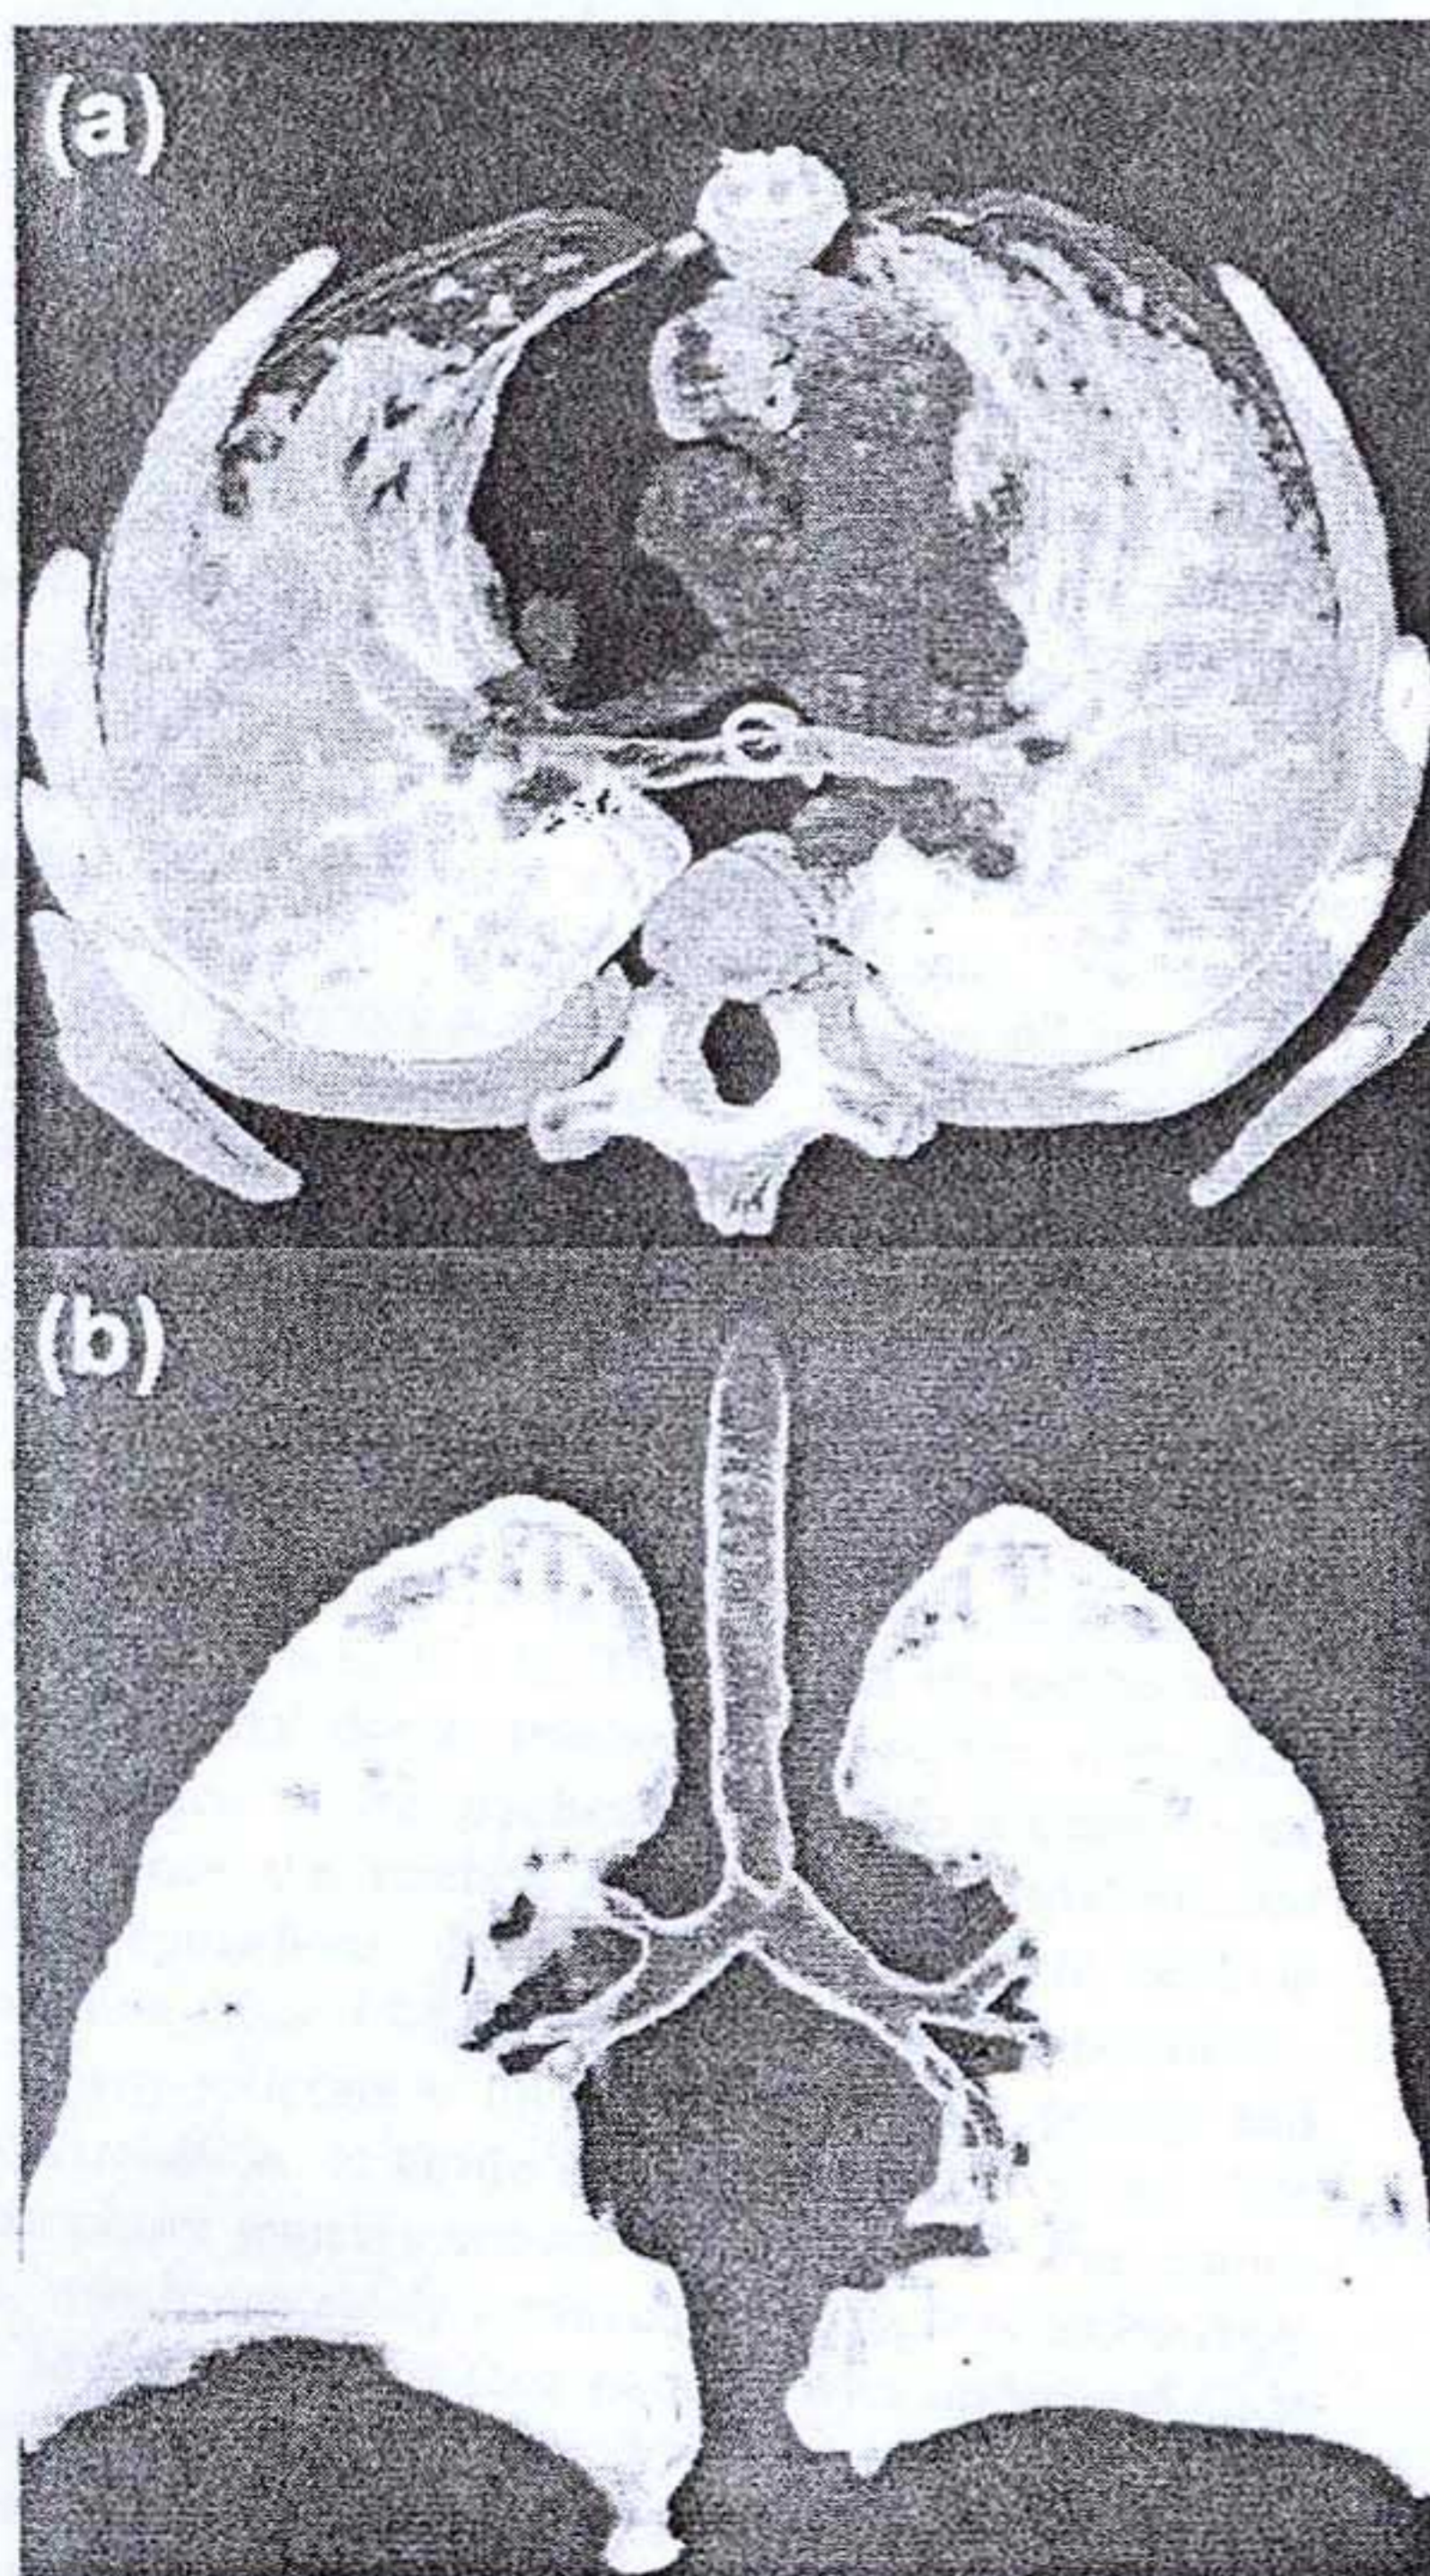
Postoperative 3D computed tomography of a 6-month-old baby after slide tracheoplasty for long-segment tracheal stenosis.
